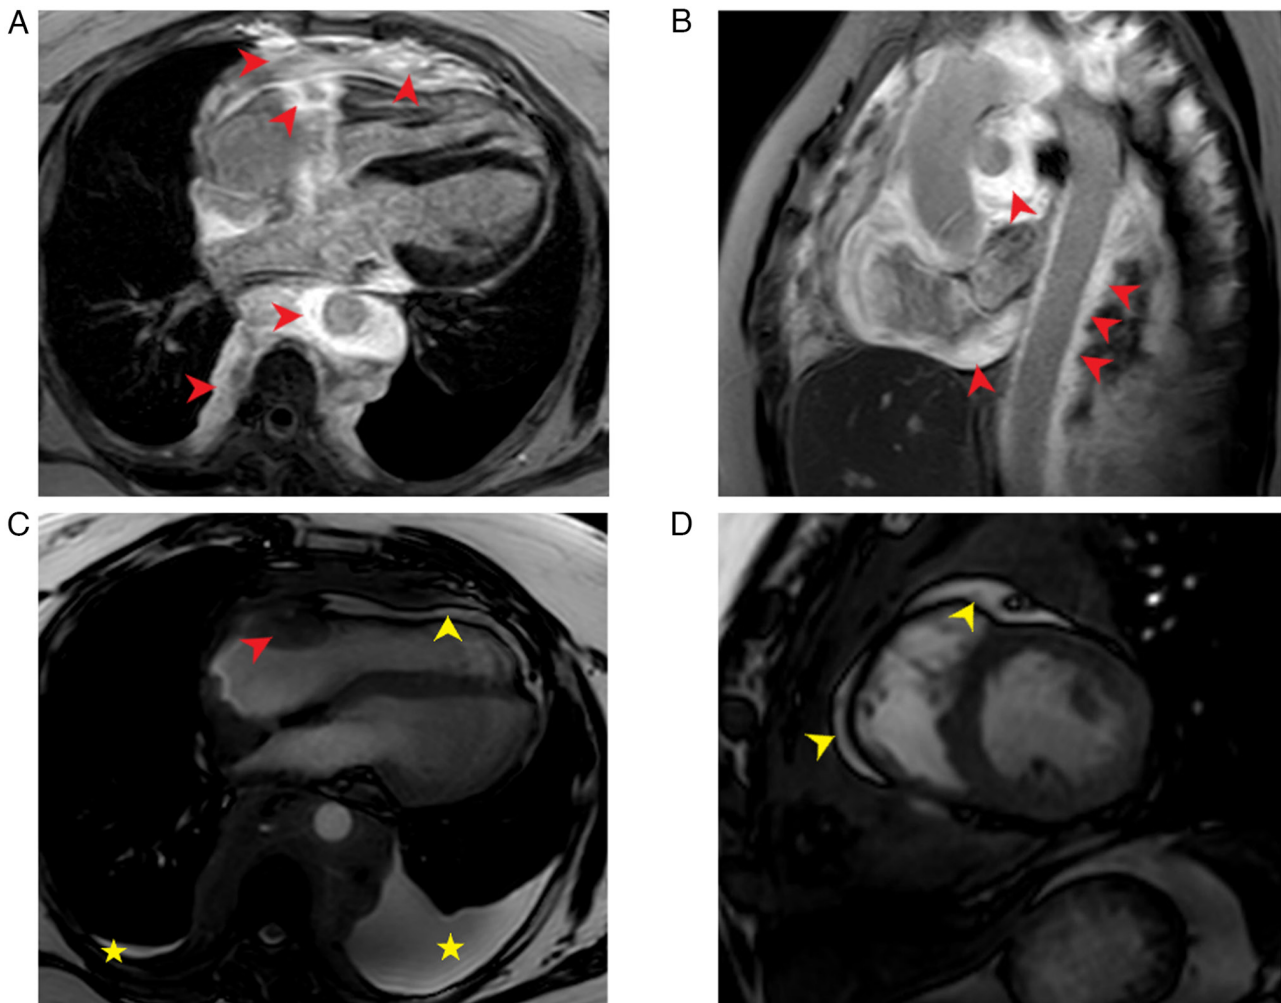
Cardiac magnetic resonance images. (A) PSIR-TFE four chamber view showing abnormal high signal around the aorta and right coronary artery, and abnormal mixed high signal in the posterior mediastinum and lateral right heart, suggestive of tissue infiltration of Erdheim-Chester disease (red arrow). (B) PSIR-TFE sagittal view shows massive thickening (non-homogeneously enhanced density) encircling the entire heart and spreading from the aortic root to the abdominal aorta (red arrow). (C) Steady state free precession four chamber view and (D) short axis view showing a mild pericardial effusion (yellow arrow) and pleural effusion (yellow star). PSIR-TFE, phase-sensitive inversion recovery turbo field echo.
